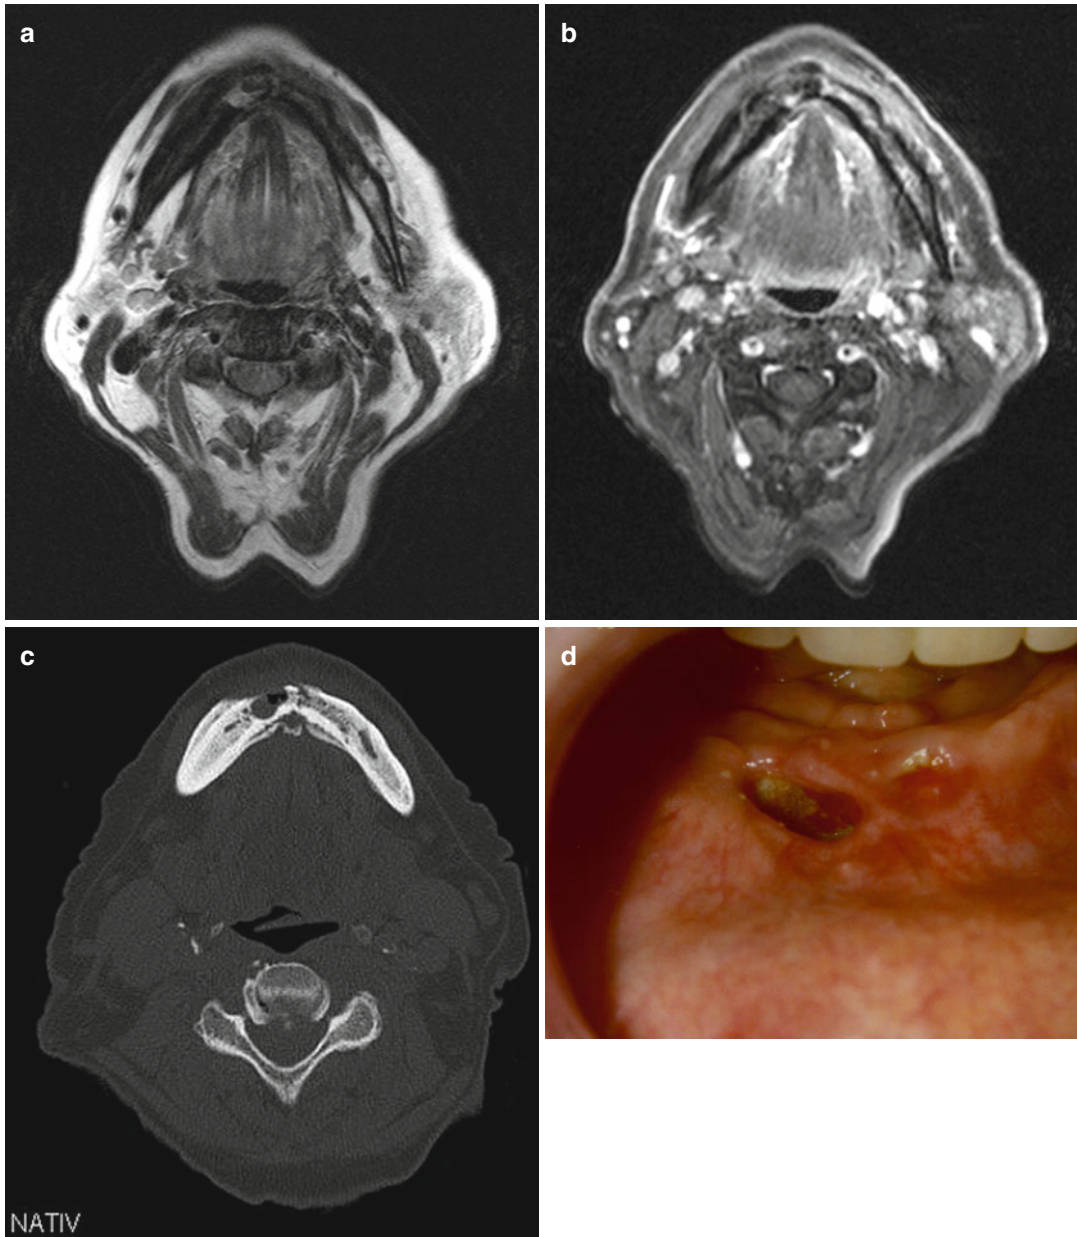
(a–d) A 50-year-old woman with breast cancer. Axial T2-weighted image (a) shows pathologic mesial fracture in the mandible as well as decreased marrow signal intensity with cortical affection and hyperostosis on the right side, accompanied by soft-tissue changes in the labial and buccal premandibular region. The soft-tissue
